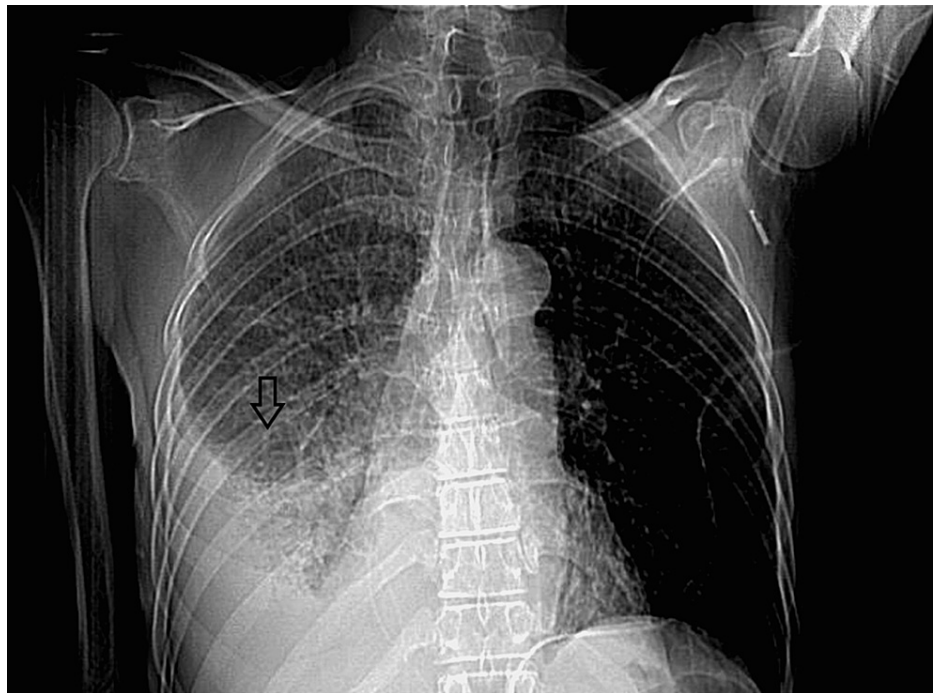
CT scan of the chest with contrast (coronal view) showing right-sided pleural effusion
